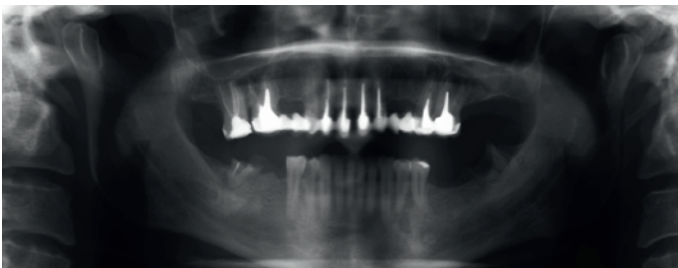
Orthopantomography provided by the patient at the first visit.
